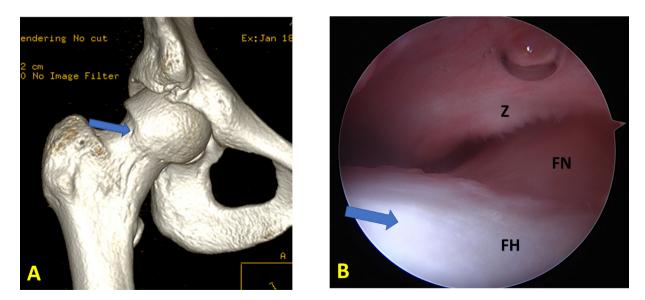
The location of the sample collection (arrow). (A) 3d-CT reconstruction image. (B) Arthroscope view. Z: Zona orbicularis; FN: Femoral neck; FH: Femoral head.
